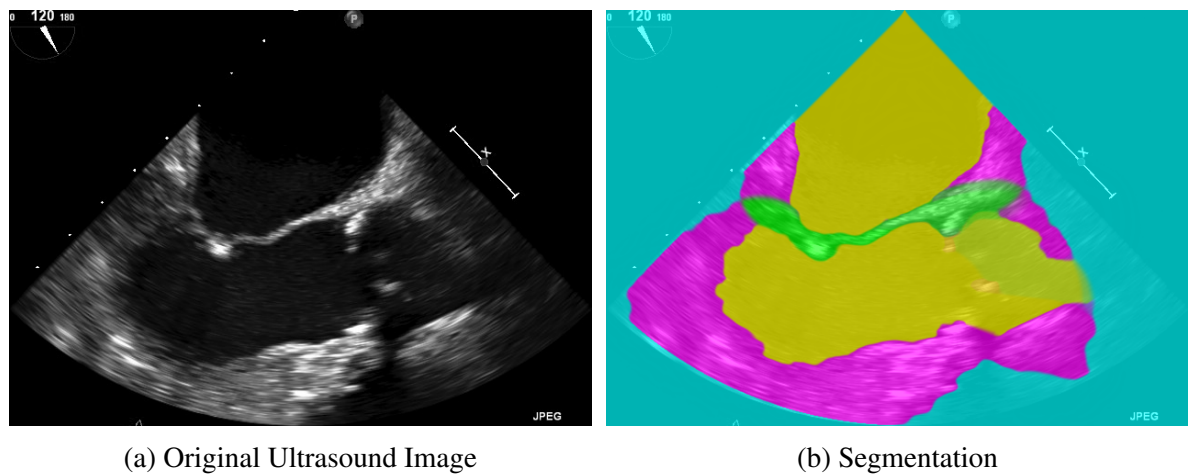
Mitral valve labelling using trans-esophageal ultrasound images. The model (Figure 6.7a - previous figure) includes label  $K$  indicates the background (in cyan),  $TW$  and  $BW$  indicates the top and bottom walls respectively (in magenta),  $TB$  and  $BB$  indicate the top and bottom blood pools respectively (in yellow), and  $V$  indicates the valve annulus.
